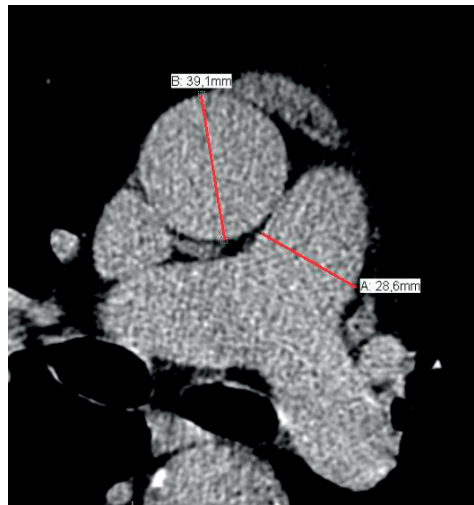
Measurement of the diameter of the pulmonary artery and aorta. This figure shows an example of the measurement of the diameter of the pulmonary artery (A: 28.6mm) and of the ascending aorta (B: 39.1mm) at the level of bifurcation of the pulmonary artery on the same slice of a non-contrast CT examination.
